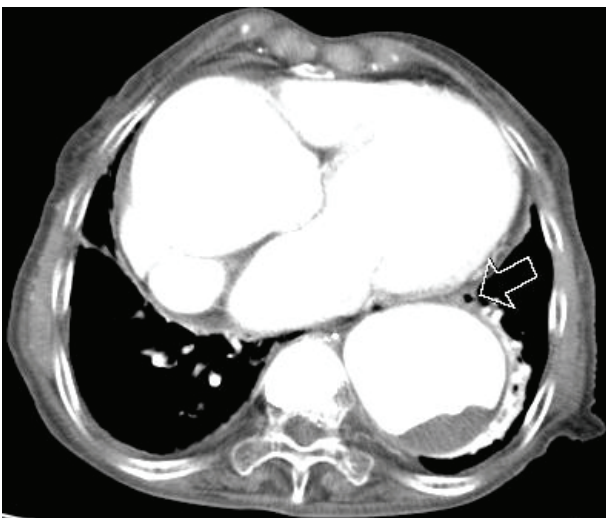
Chest computed tomography showed an enlarged thoracic aorta with an intramural thrombus at the level of the descending aorta. Note that the distorted esophagus was displaced to the anterolateral aspect of the descending aorta (arrow).
